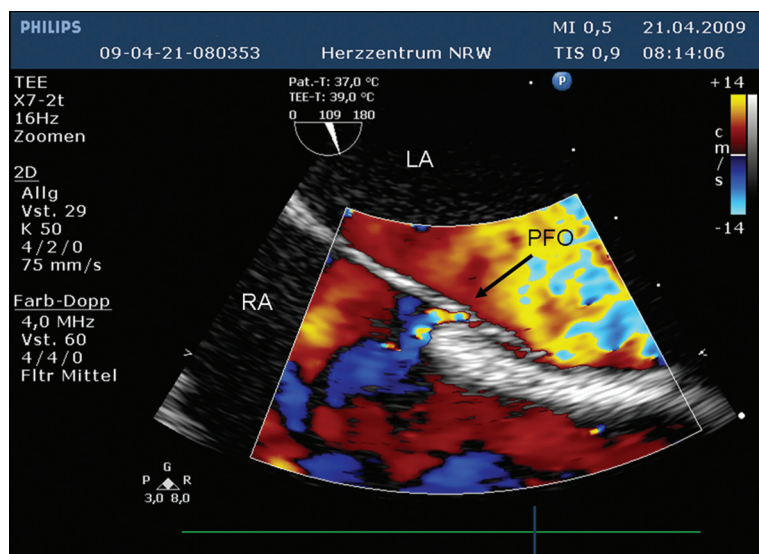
2-D and Color Doppler transesophageal echocardiographic examination. Patent Foramen Ovale with left to right shunt. LA – left atrium, RA – right atrium, PFO – Patent Foramen Ovale.
